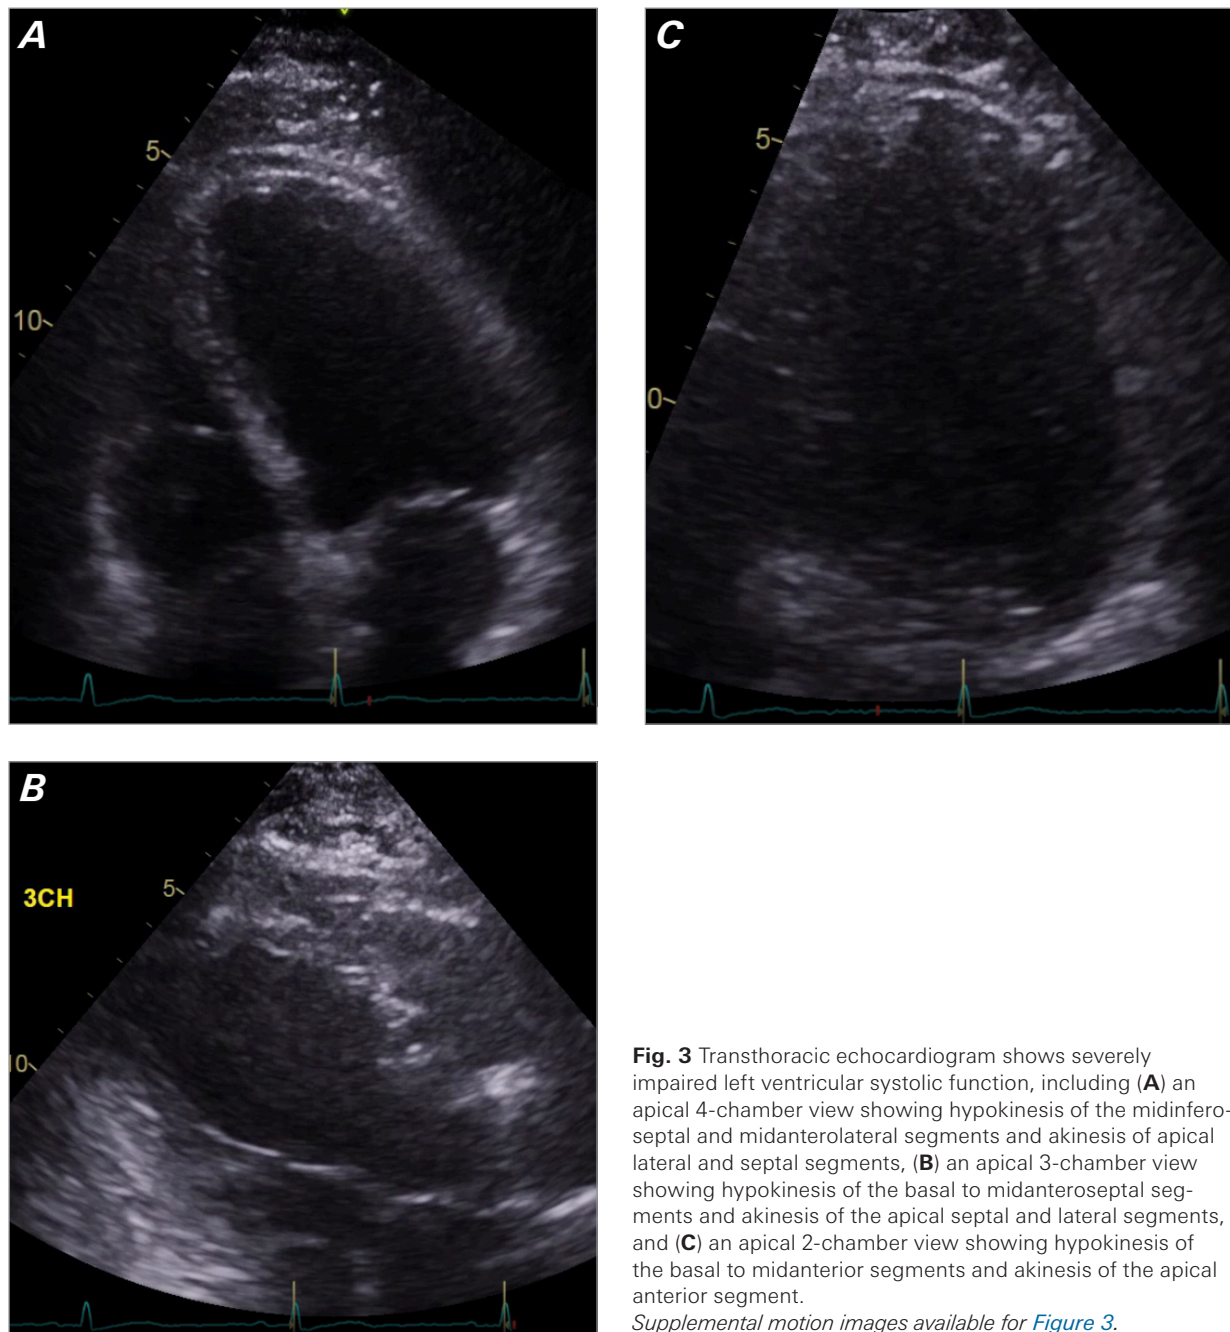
Transthoracic echocardiogram shows severely impaired left ventricular systolic function, including (A) an apical 4-chamber view showing hypokinesis of the midinferoseptal and midanterolateral segments and akinesis of apical lateral and septal segments, (B) an apical 3-chamber view showing hypokinesis of the basal to midanteroseptal segments and akinesis of the apical septal and lateral segments, and (C) an apical 2-chamber view showing hypokinesis of the basal to midanterior segments and akinesis of the apical anterior segment.
